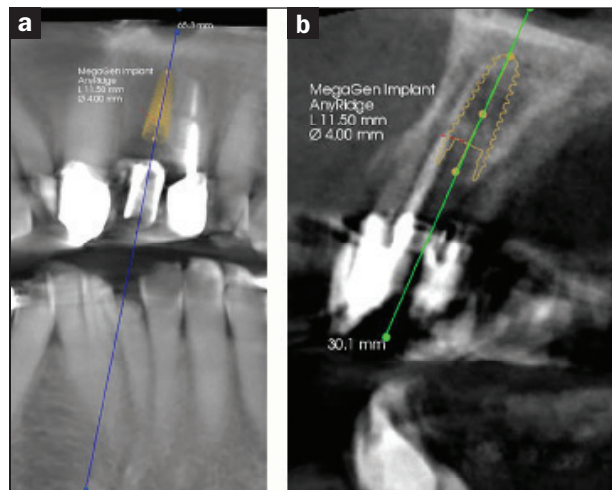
A CBCT scan (tangential and cross-sectional views) prior to correction of the guide sleeve in the planning software indicated the trajectory of the implant if the sleeve was followed, which would have resulted in thin bone on the palatal surface.
